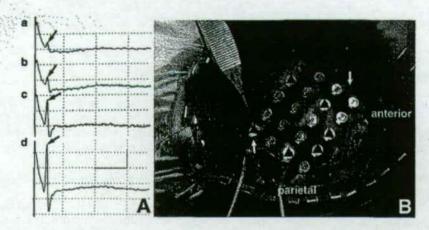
A: Representative D-waves (arrows) classified into amplitudes of under 2 μV (a), 2 to 5 μV (b), 5 to 10 μV (c), and over 10 μV (d). Time scale, 5 msec; amplitude, 5 μV. B: Photograph of the intraoperative epidural grid electrode placed over the sensory, primary motor, and premotor cortices in Case 1. The amplitude of the D-wave evoked by the stimulation of each plate electrode was classified as over 10 μV (open circles), 5 to 10 μV (open squares), 2 to 5 μV (open triangles), and under 2 μV (closed triangles). Thick line: Central sulcus estimated by magnetic resonance imaging-guided navigation.
